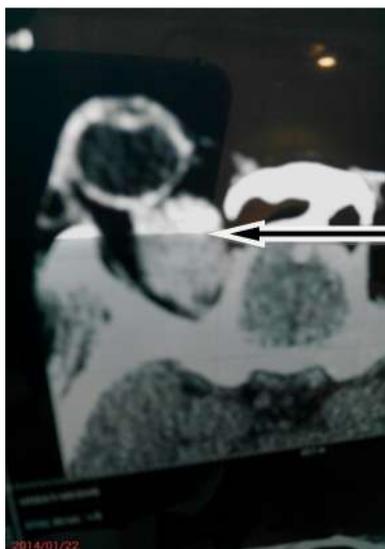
CT scan showing a well defined mass in the left orbital cavity (arrow)
